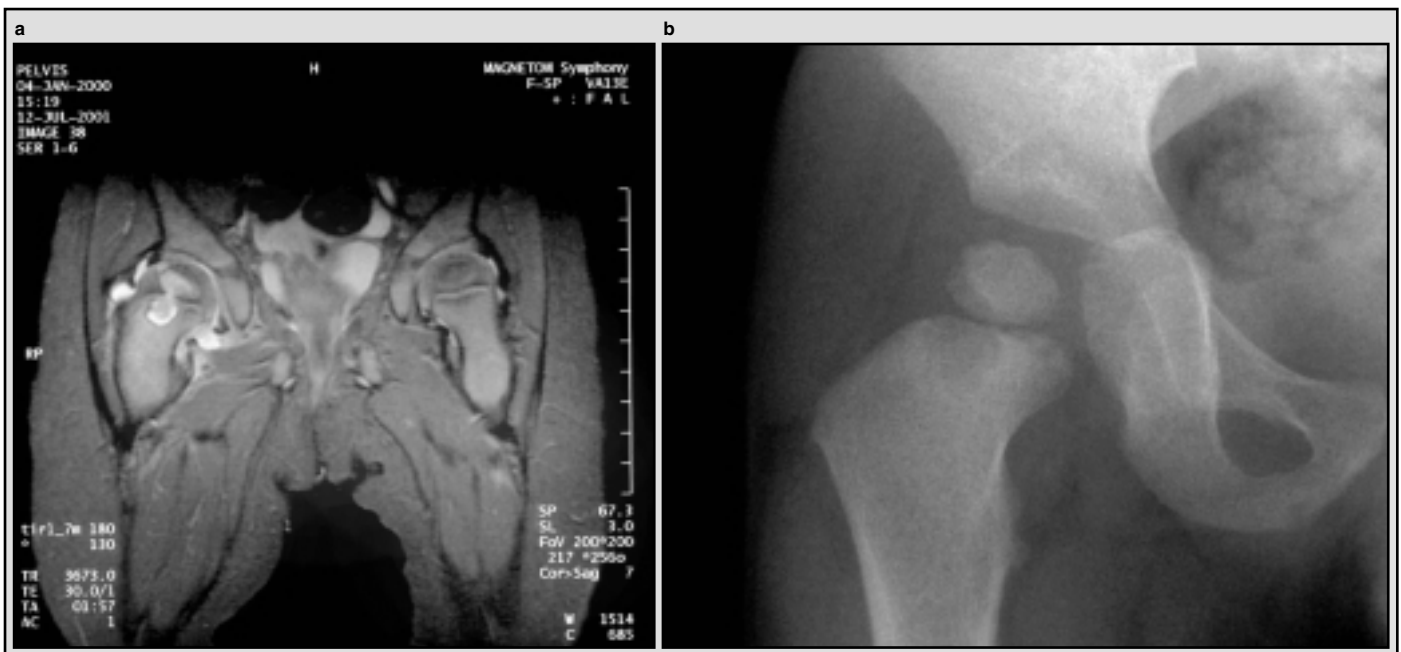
An 18-month-old child who presented with fever and limp. (a) T2-weighted magnetic resonance imaging with fat suppression shows a focal area of signal abnormality in the proximal femoral metaphysis consistent with a Brodie abscess. There is extension through the physeal plate in the epiphysis. (b) Plain radiograph shows a destructive lesion in the femoral metaphysis.
